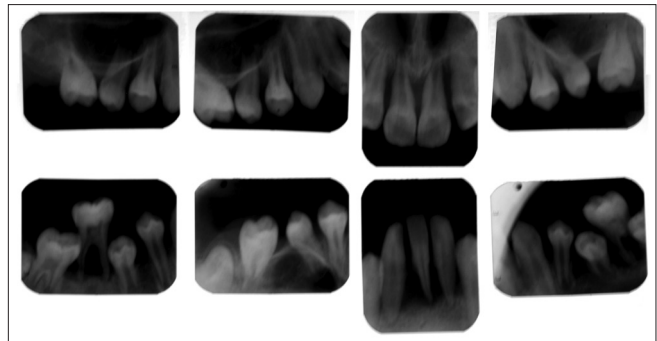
Full mouth intraoral periapical radiographs showing bone loss up to apical one-thirds of teeth
